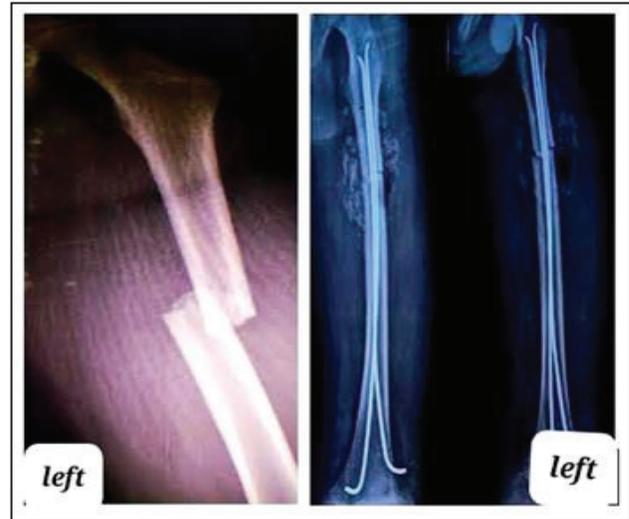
Pre and post operative radiographs of shaft of femur fracture of 10-year-old child, managed with elastic nail
